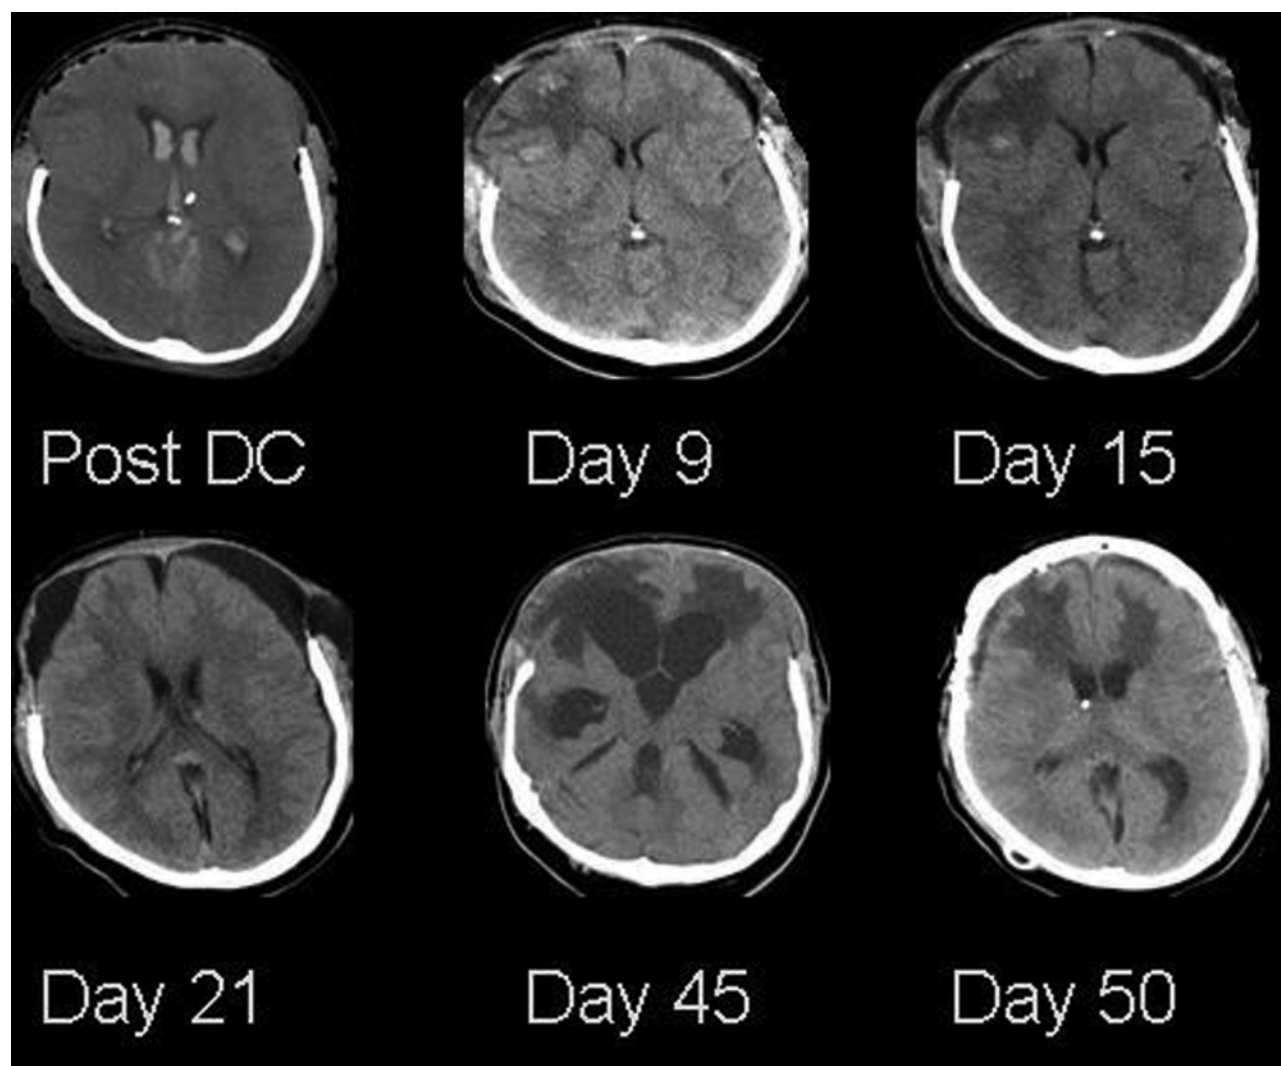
Computed tomography scans obtained in a 19-year-old man following an MVA, who underwent DC for sustained high ICP (22.5 mm Hg) and a right frontal blossomed contusion. Three axial CT scans obtained on Days 9, 15, and 21 showed the gradual appearance of an SDG. The hygroma was absent on a CT scan obtained 24 days later (Day 45), although there was evidence of hydrocephalus. A shunting device was inserted, and autologous cranioplasty was performed 2 days later. Three months after his accident the patient remained severely disabled (GOS Score 3).
